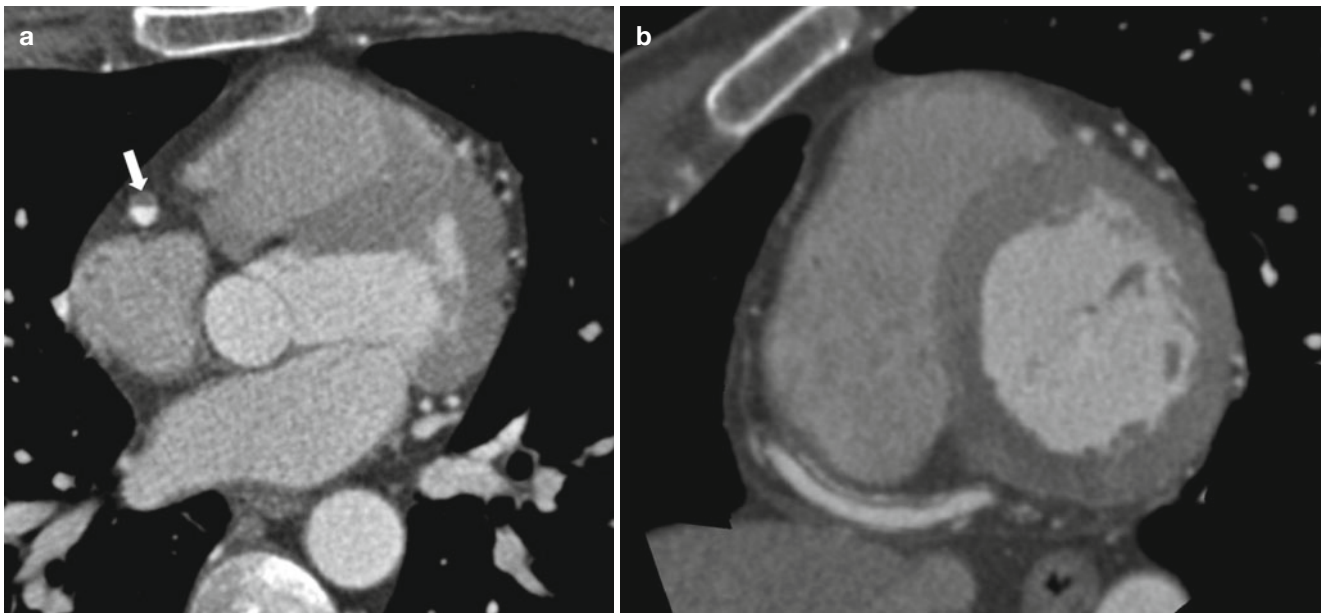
A 46-year-old man with an iatrogenic coronary artery dissection. (a) The coronary CT angiography after failed percutaneous coronary artery intervention shows coronary artery dissection and an intimal
